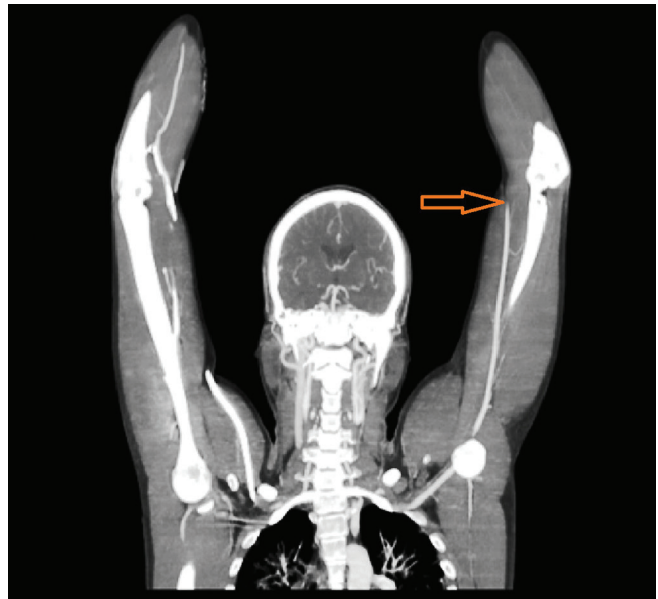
CT angiogram of patient with signs of acro-ischemia showing abrupt cutoff of distal left brachial artery, beginning approximately 3.5 proximal to the elbow joint
